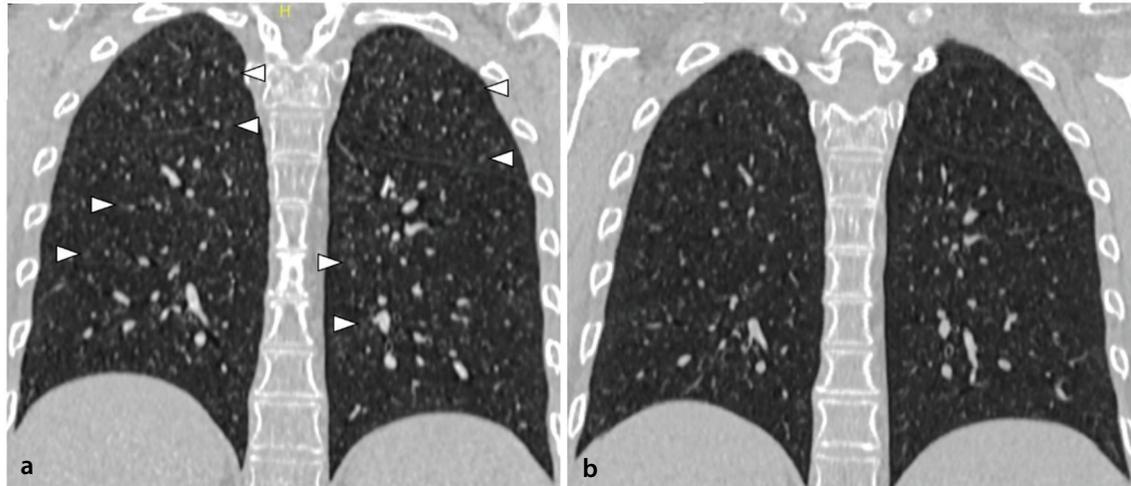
A 31-year-old female patient with acute myeloid leukemia. One week after receiving cytosine arabinoside (Ara-C) chemotherapy, a non-enhanced chest computed tomography (CT) was performed with complaints of low-grade fever and mild dyspnea. (a) Coronal plane chest CT shows bilateral upper lobe predominant centrilobular ground-glass nodules (arrowheads). The case was discussed in a multidisciplinary meeting due to the suspicion of miliary tuberculosis. Since all microbiological examinations were negative and clinical presentation was mild, the findings were primarily attributed to the Ara-C effect. After stopping chemotherapy, her symptoms regressed. (b) Follow-up chest CT 1 month later reveals almost complete resolution of radiological findings.
